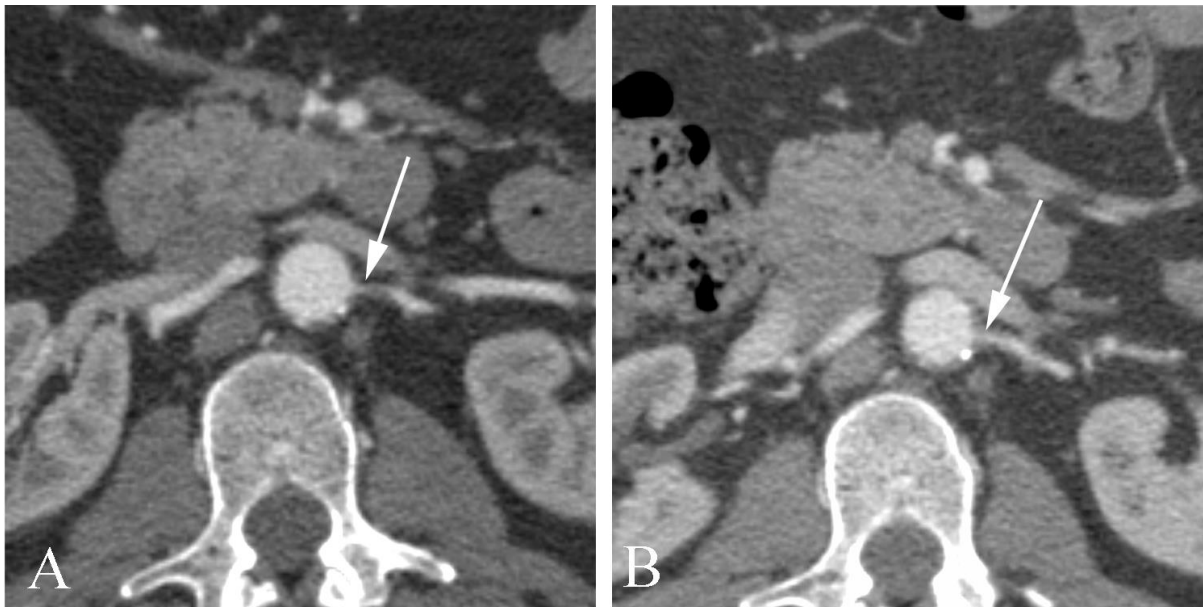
Renal artery stenosis treated with angioplasty in a 54 year old with hypertension. A. Initial CT angiogram (left) shows stenosis of the left renal artery (arrow). B. Follow-up CT following angioplasty shows decreased stenosis (arrow). The patient's hypertension was under better control with fewer medications following angioplasty.
